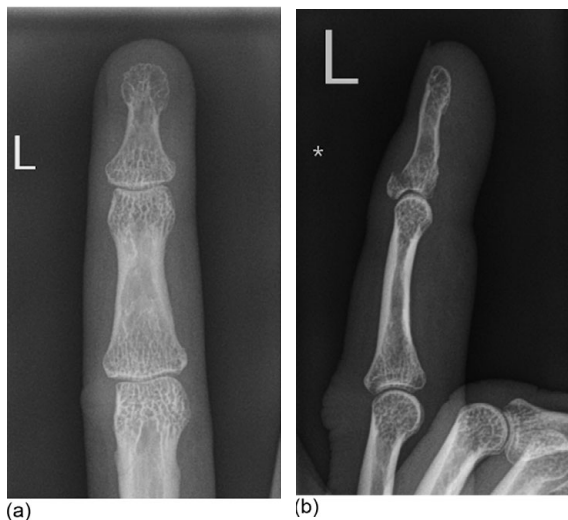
(a) Anteroposterior and (b) oblique radiograph finger
